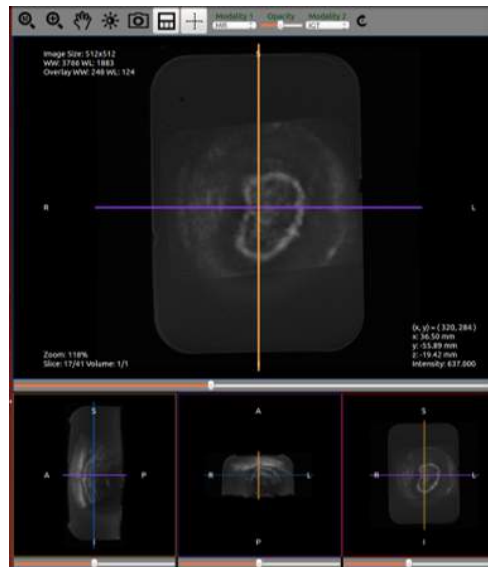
Visualization of a reconstructed US volume (with MRI as overlay).
